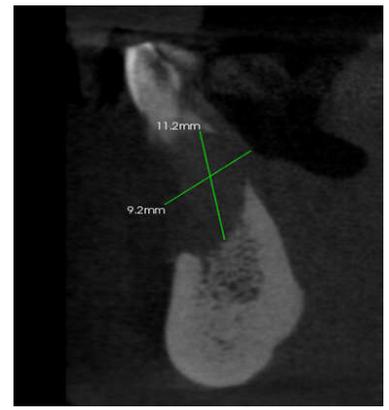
Saggital view cbct
